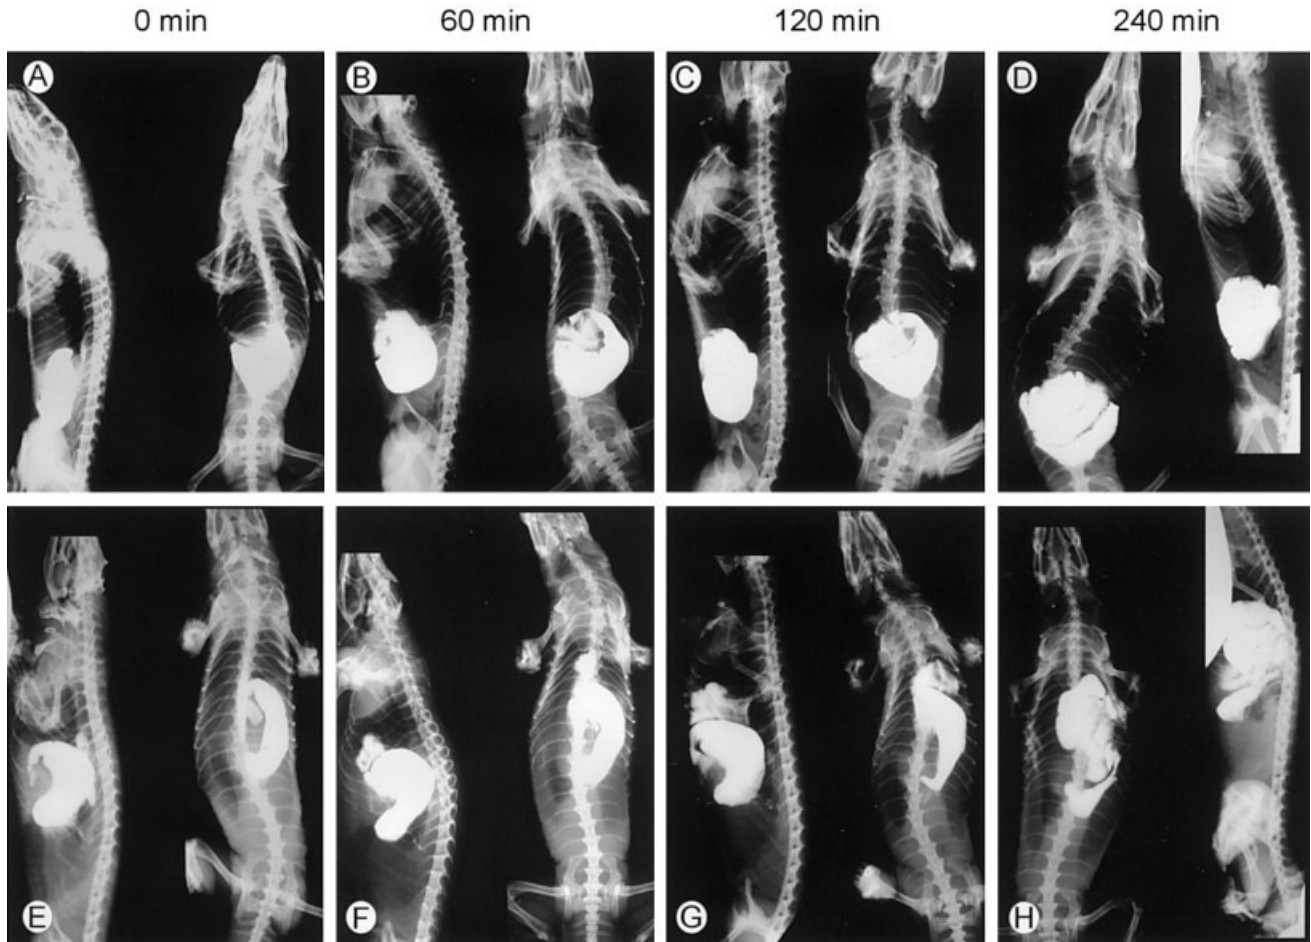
X-ray images of *Tupinambis merrianae* with intact PHS (A–D) and with removed PHS (E–H) immediately, 60, 120, and 240 min after injection of barium sulfate into the stomach. The left part of each picture shows an image made in lateral–right direction and the right part taken in dorsoventral direction. Note the clear localization of stomach and intestine caudal to the PHS in the intact tegu (A–D) and the lack of this organization in the tegu without PHS (E–H).
